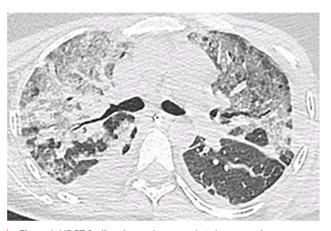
HRCT findings in monkeypox-related pneumonia
